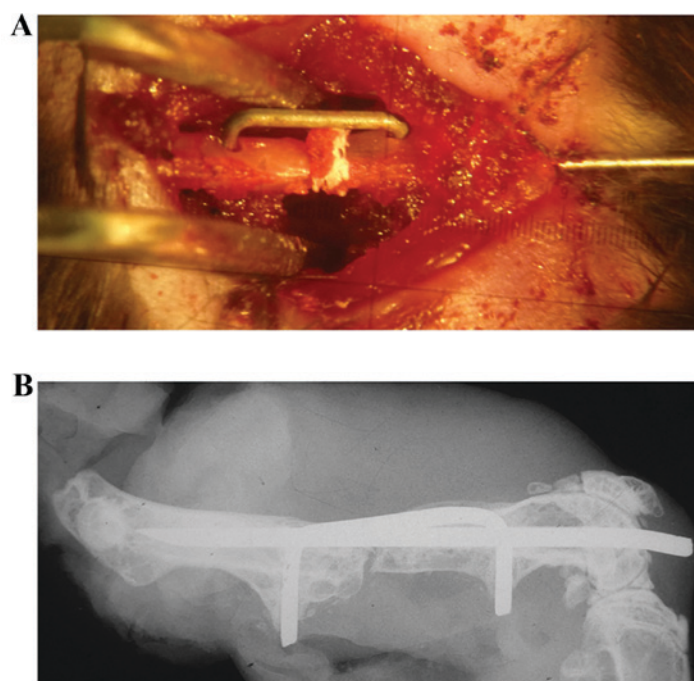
Establishing a femoral bone defect model. (A) Intramedullary needle and custom-made clip were implanted into the femur to fix the bone defect. (B) Post-operative X-ray analysis.
